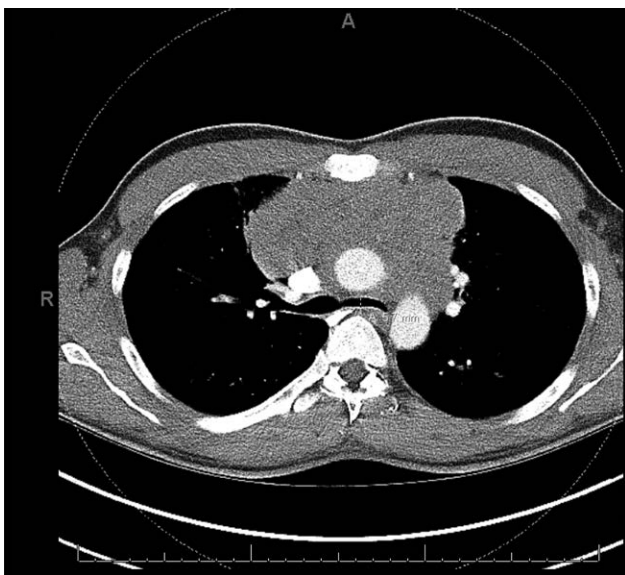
Computed tomography of the chest with intravenous contrast in the axial plane demonstrating narrowing of the left main bronchus to 5.7 mm.
